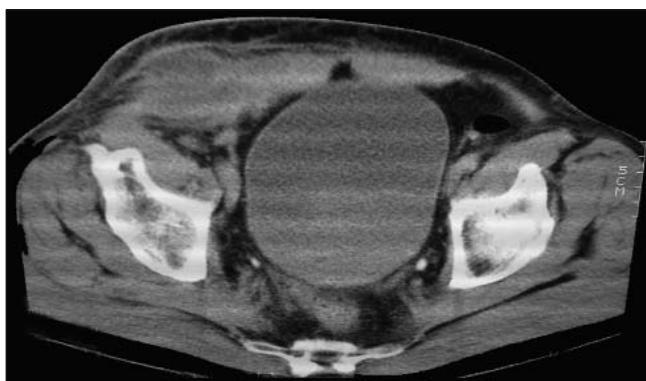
CT shows a preperitoneal mass about 3 cm in diameter
